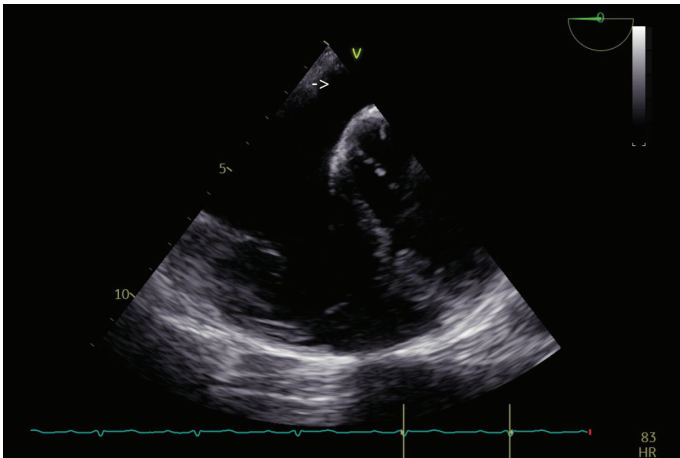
Transesophageal echocardiography shows a dilated coronary sinus (arrow).
